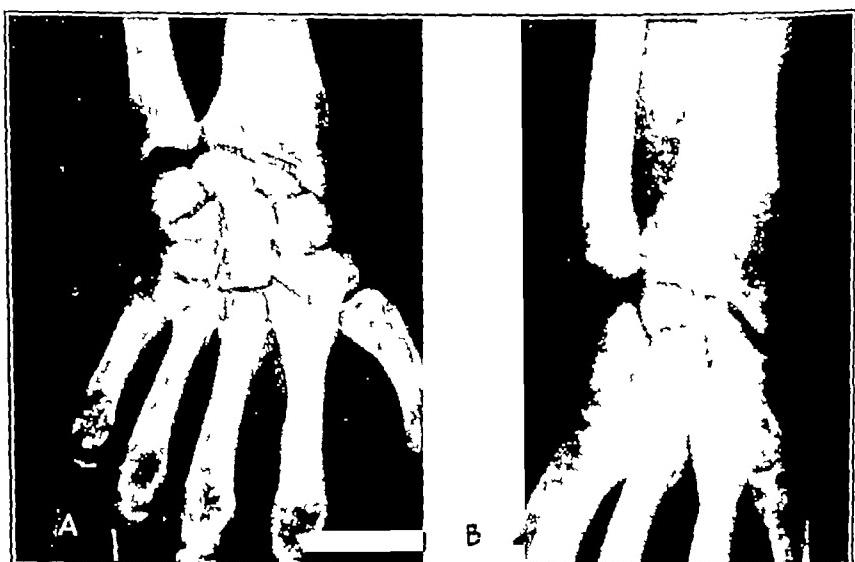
(case 17)—*A*, roentgenogram taken Jan 9, 1945, six months after the injury, discloses an old fracture across the scaphoid, with nonunion. There is slight separation of the fragments. *B*, bone peg in place. Position and alignment of the fragments are good.
